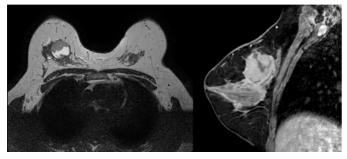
T2-weighted (T2W) T2w turbo-spin-echo (TSE) and bilateral imaging in the sagittal plane using sensitivity encoding (SENSE) of the right breast (BLISS)
